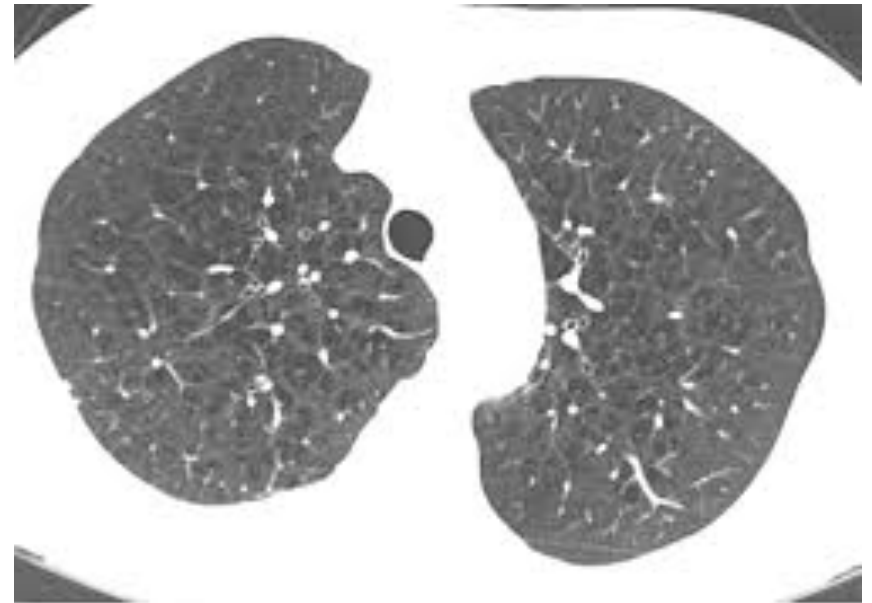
Centrilobular Emphysema in a Cigarette Smoker. Axial CT image through the upper lungs shows numerous well-defined lucencies, many of which are traversed by a central vessel.
